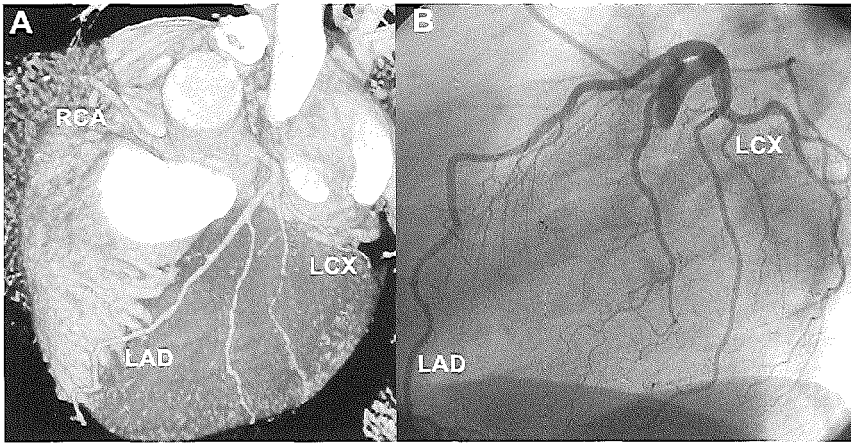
Volume rendered multislice CT (A) and conventional coronary angiogram (B). The left anterior descending coronary artery (LAD), including the proximal, intermediate, and diagonal side branches, and the small circumflex artery (LCX) can be assessed. Also, the proximal right coronary artery (RCA) can be observed. Interruptions are introduced by the volumerendering technique in the small distal intermediate branch.
